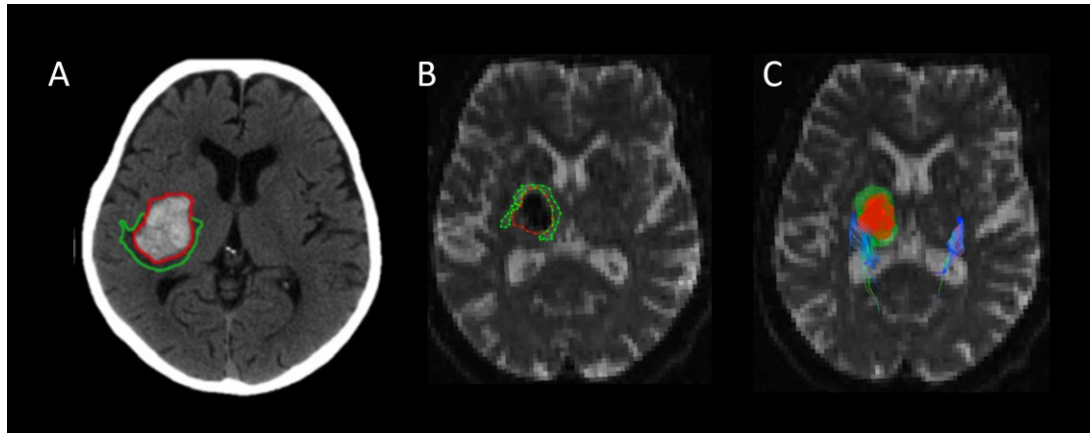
Measuring edema and hematoma. A) Regions of interest (ROIs) for hematoma (red) and edema (green) volumes are drawn planimetrically on the acute and 24h CT. B) ROIs are drawn on the ‘Mean of $b=0$ s/mm²’ map. Green indicates edema, red the hemorrhage. C) The corticospinal tract is shown in blue in three-dimensions, adjacent to the hematoma and edema masks.
